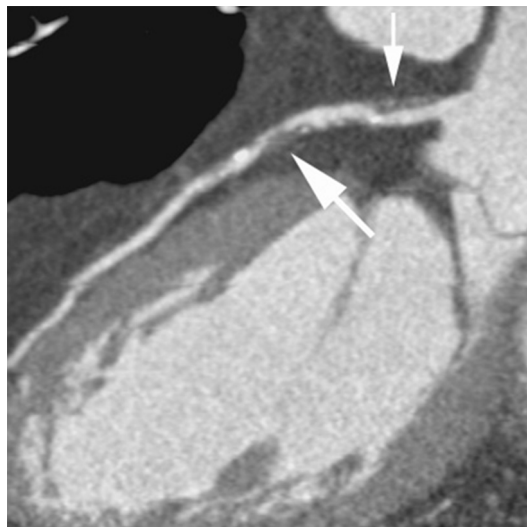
Example of computed tomography angiogram demonstrating stenosis and atherosclerotic plaque in the left anterior descending artery (white arrows).
